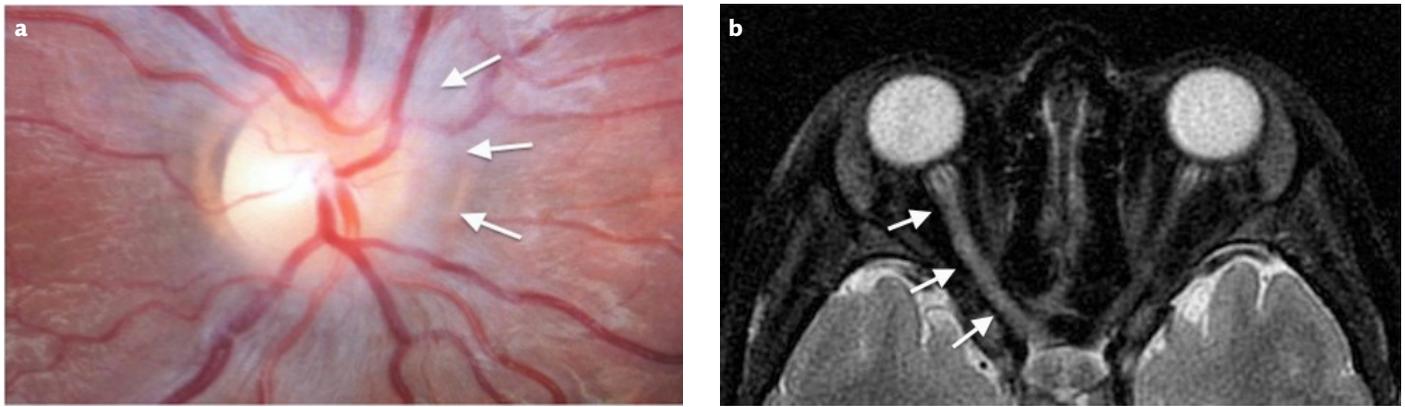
Optic neuritis. Retinal examination revealed hyperemia of the optic disc with slightly indistinct borders in the right eye (arrows) (a). The right optic nerve along the intraorbital, intracanalicular, and chiasmatic segments is with increased calibration and signal intensity on T2-weighted fat saturated axial orbital MR image (b).
